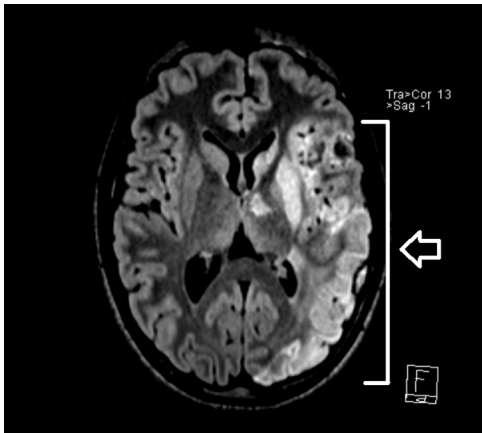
Axial 3D-FLAIR image showing the extent of the ischemic stroke (white arrow).
